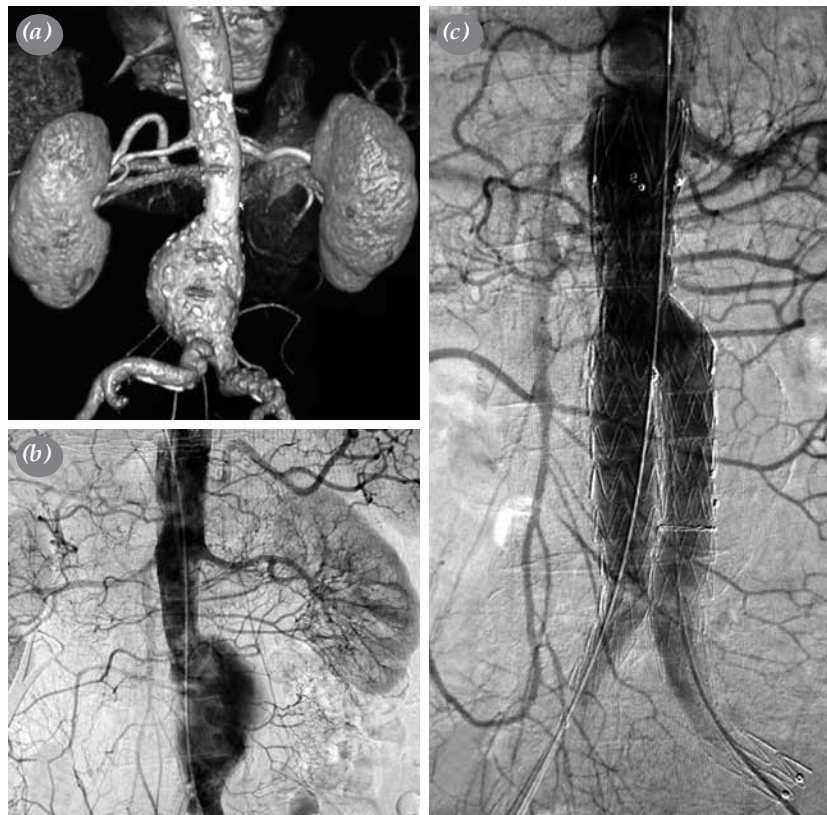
Images of an abdominal aortic aneurysm. (a) Preoperative three-dimensional reconstruction of contrasted computed tomography imaging. (b) An intraoperative double subtracted angiography image. (c) A postoperative double subtracted angiography image.
